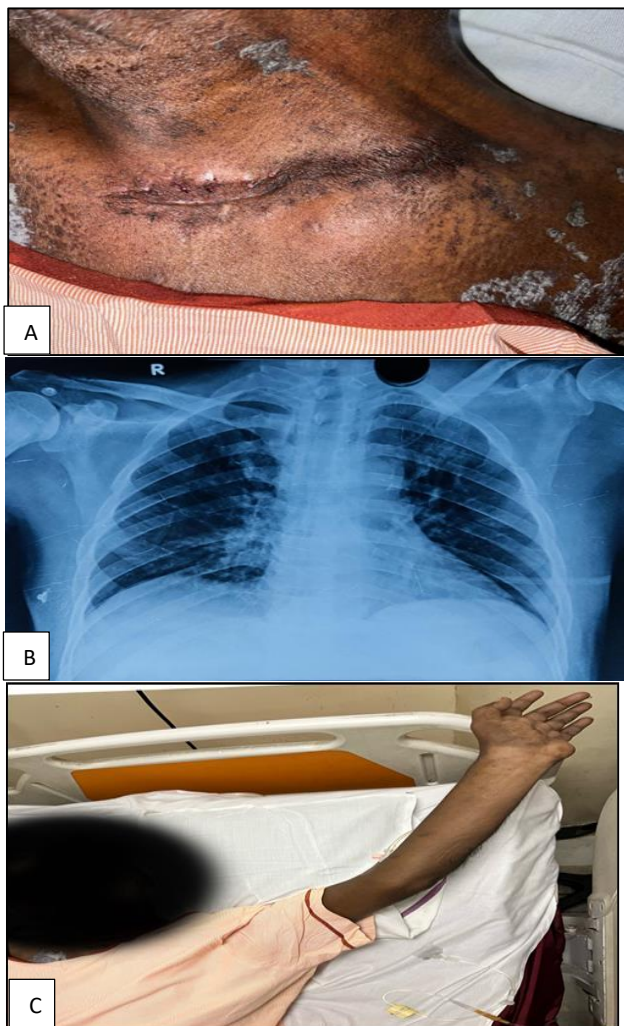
(A-C): Healed surgical wound at six weeks post op, radiographs taken at six weeks follow up and pain free abduction at six weeks follow up.
